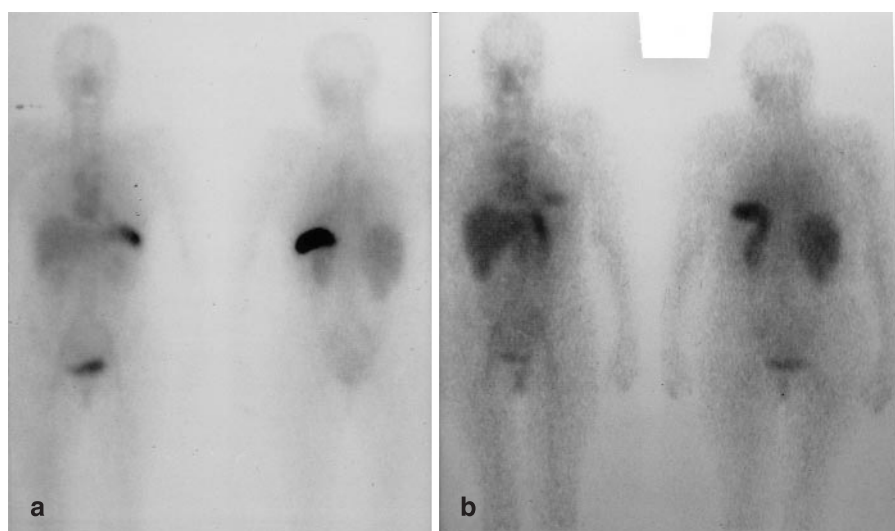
Serial anterior (*left*) and posterior (*right*) whole body ¹²³I-SAP scintigraphy in a patient with FAP (Table 2, patient 8) before (a) and 12 months after (b) OLT, showing modest regression of amyloid deposits in the spleen but not the kidneys
